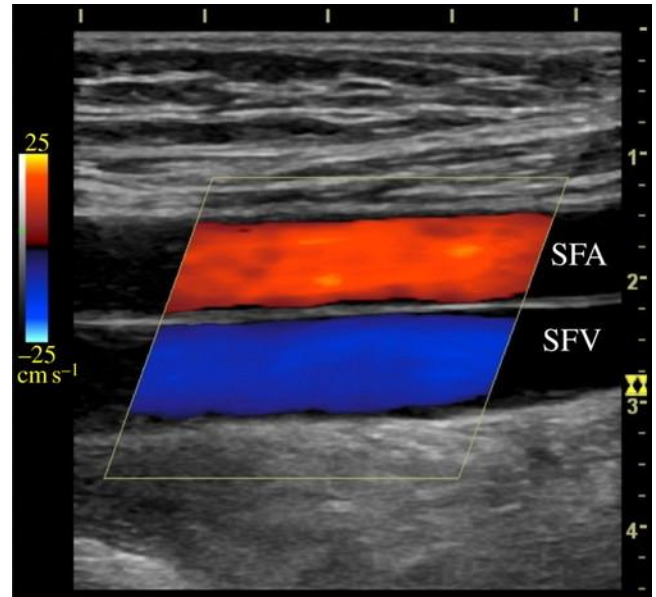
Colour flow image obtained by superimposing Doppler information on the pulse-echo image. The subject's head is to the left of the scan, and so the arterial flow is from left to right and the venous flow from right to left. The colour scale is calibrated in cm s^{-1} and shows that flow towards the probe is coloured as red-orange-yellow, while flow away from the probe is coloured in shades of blue. The angle of the colour box is inclined at an angle to the vertical to ensure that the Doppler angle is different from 90° .
